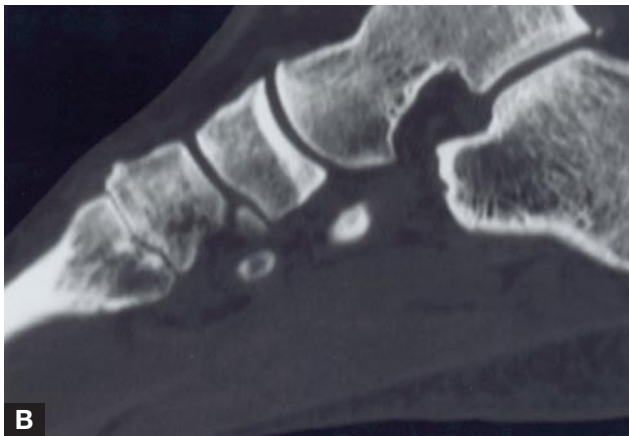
Images of a woman in her mid-40s with significant foot pain in the second tarsometatarsal joint. Clinical examination revealed localized tenderness in this area. (A) X-ray shows degenerative changes in the second tarsometatarsal joint with marked obliteration of the joint space and subchondral sclerosis. (B) Computed tomography scan shows extensive arthritis in the second tarsometatarsal joint with preservation of the adjacent joints. After conservative treatment failed, the patient underwent a second tarsometatarsal joint arthrodesis. (C) X-rays 1 year after surgery show solid fusion of the joint. The patient was pain-free and had returned to all activities.
